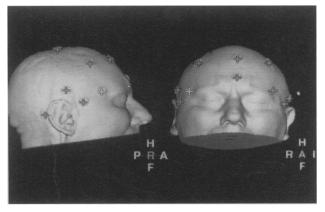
Three-dimensional segmentation of patient's head from MR images showing distribution of scalp fiducial markers, appearing as crosses after registration is complete.
